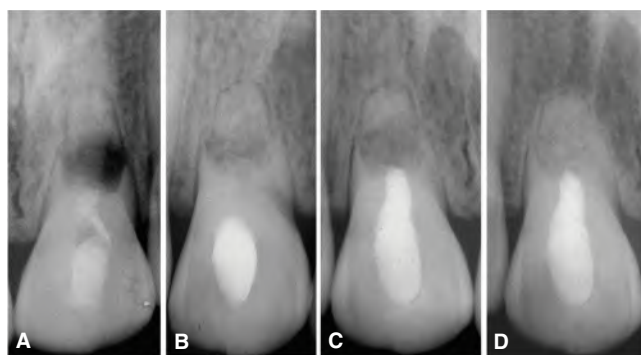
Nonsurgical endodontic retreatment in a traumatized maxillary central incisor of an 18-year-old male. On examination, the tooth was mobile and symptomatic on biting. A. Preoperative radiograph showing a large middle root radiolucency. Extensive root defect associated with the affected tooth is observed. B. Radiograph showing calcium hydroxide intracanal medication in place. C. Immediate postoperative radiograph. The root canal was obturated with gutta-percha and sealer. D. Three-year follow-up radiograph showing resolution of the radiolucency. The tooth is asymptomatic and mobility restored to normal.
